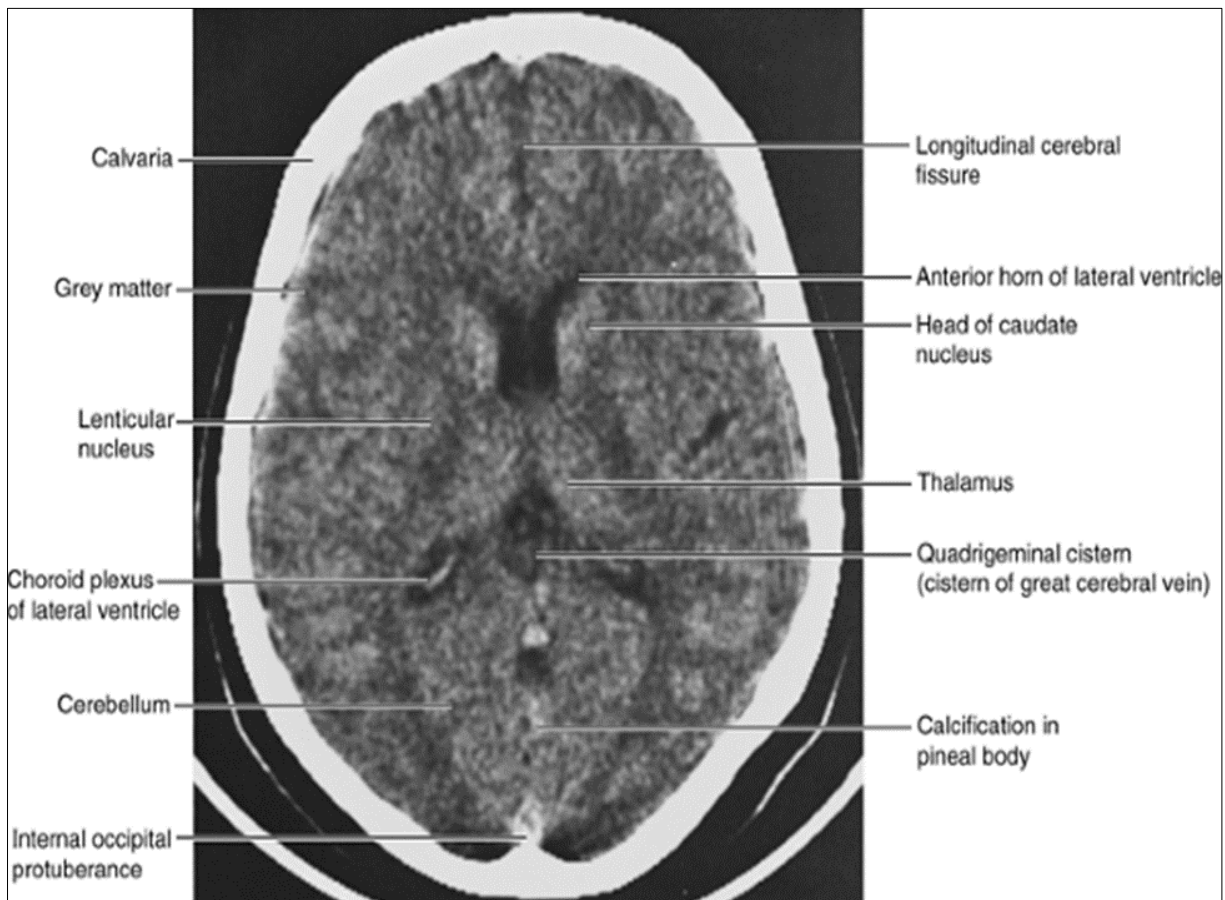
Cranial CT showing a transverse slice of the brain. *Courtesy; Keith Moore & Arthur Dalley*
